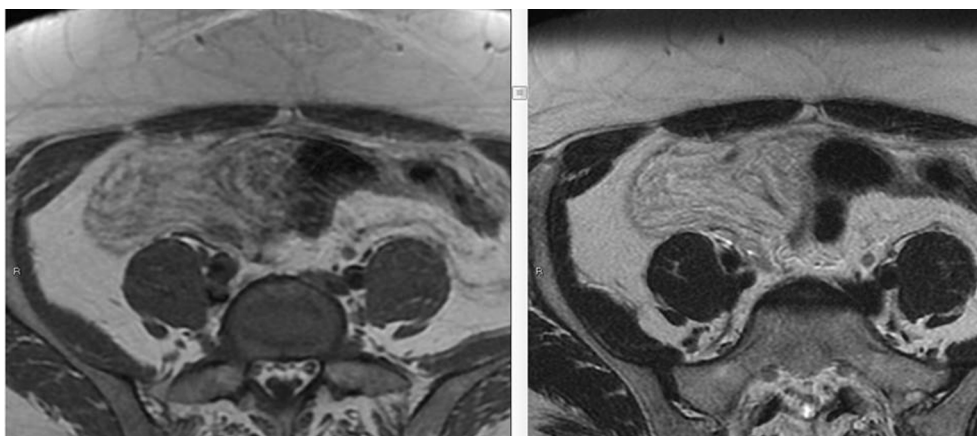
Pelvic MRI (axial T1 and T2) showing fat stranding and thickening of both peritoneal folds.
